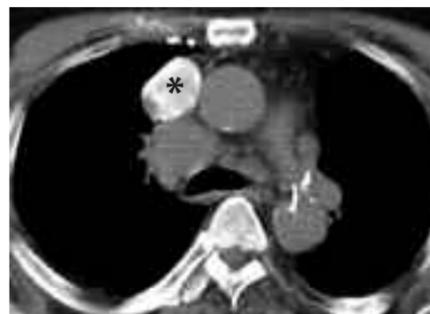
Good enhancement of the mediastinal lymph node in internal thoracic arterial injection CT.
